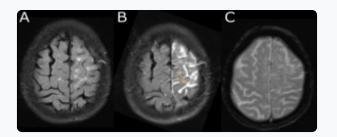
Pre-interventional FLAIR sequence (A). Post-gadolinium injection FLAIR sequence (B) with apparition of FLAIR hyperintensity in the subarachnoid spaces of the left cerebral convexity. (C) Normal T2 gradient echo sequence, showing no blood products.
